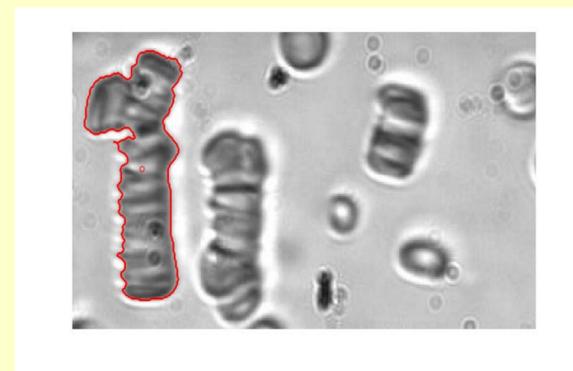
X-Ray image with rouleau outlined in red (see Fig. 8 for print)
